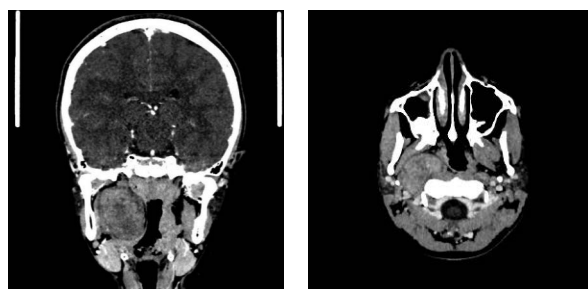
Tumour on CT scan with contrast
